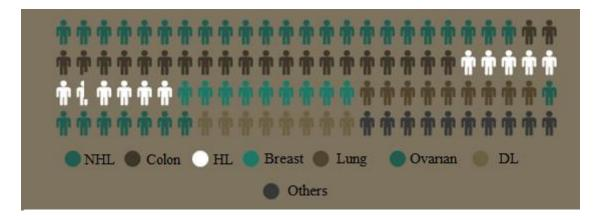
Clinical indications of <sup>18</sup>F-PET-CT exams performed by type of cancer
